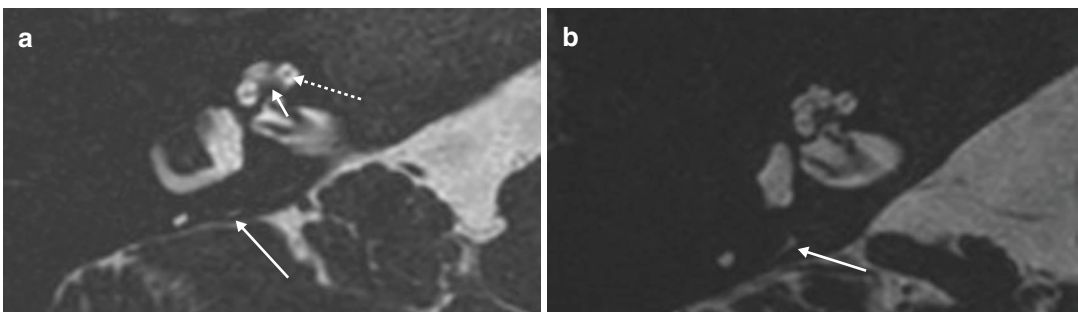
(a, b) Magnetic resonance imaging findings showing normal modiolus (small white arrow) and osseous spiral lamina (dotted white arrow). Note that the normal sized vestibular aqueduct (straight long white arrow) is difficult to appreciate with MR imaging
